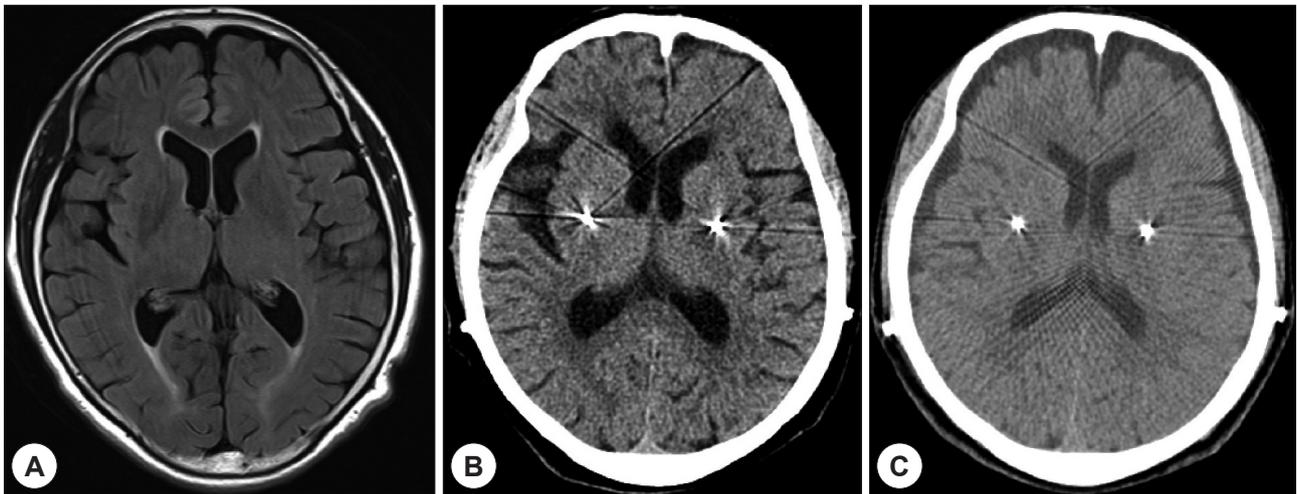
A : Pre-operation magnetic resonance imaging (MRI) shows mild cortical atrophy. B : Post-operation computed tomography (CT) scan shows no abnormalities. C : CT scan on 7th postoperative day shows minimal bilateral hygroma possibly due to cortical atrophy.
